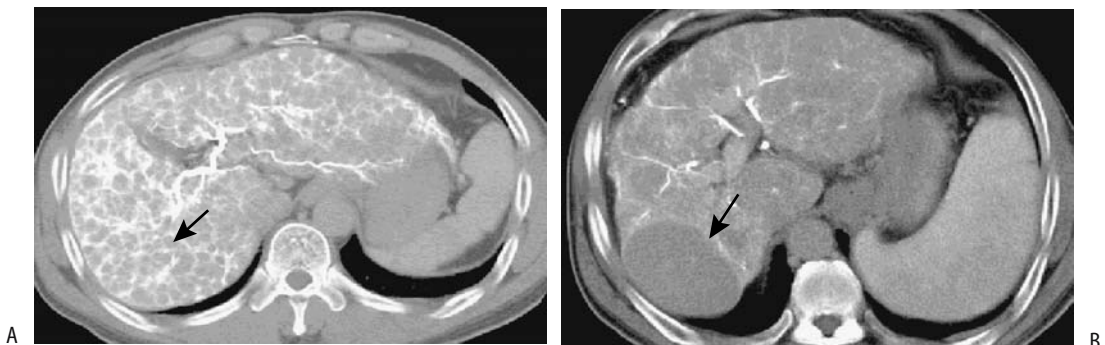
High-grade dysplastic nodules. A: CT arterial portography reveals a right lobe tumor (arrow) that is enhancing similarly to adjacent liver tissue. B: The tumor enhances less during CT hepatic arteriography than liver parenchyma. (Source: Kim HC, Kim TK, Sung KB, et al. CT during Hepatic Arteriography and Portography. *RadioGraphics* 2002;22:1041–1051, with permission from the Radiological Society of North America.)
